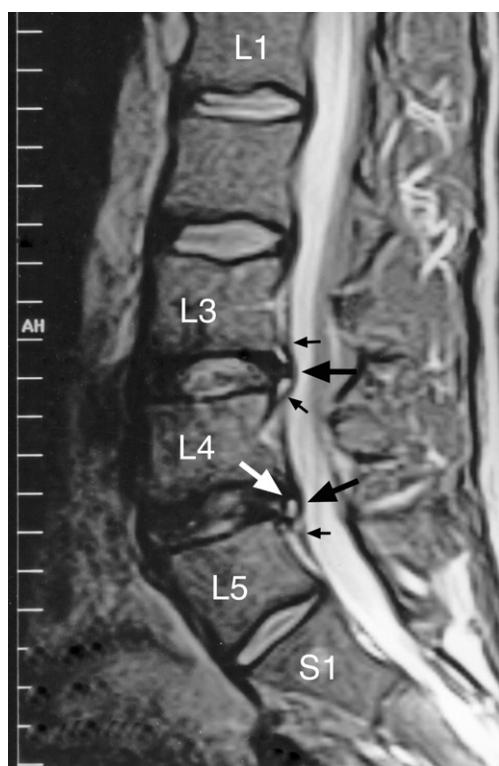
Lumbar spine MRI sagittal T2-weighted image showing posterior disc protrusions at the L3–4 and L4–5 levels (black arrows). At the L3–4 and L4–5 levels the posterior intervertebral disc protrusions elevate the posterior longitudinal ligament (small black arrows). The L4–5 intervertebral disc has a posterior tear with a high intensity zone (white arrow).
